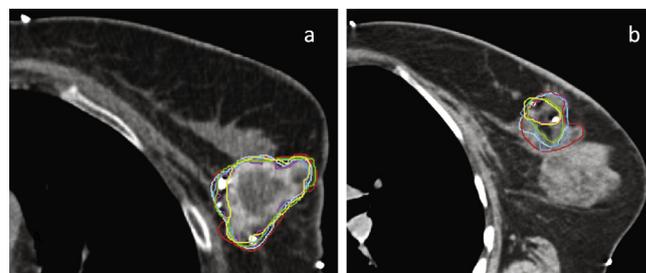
a/b: Example of tumor bed delineation on CT with (a) and without (b) hydrogel.
